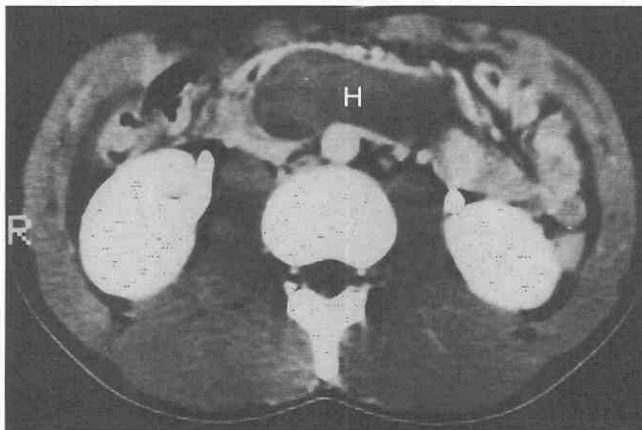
Intramural duodenal hematoma after blunt abdominal trauma. CT scan shows a sausage-like cystic lesion (H) in the wall of the duodenum.
